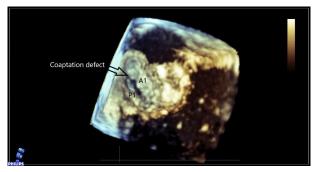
Case 2: 3D transesophageal echocardiographic image of mitral valve coaptation defect from atrial side. A1, A1 scallop of mitral valve; P1, P1 scallop of mitral valve.
